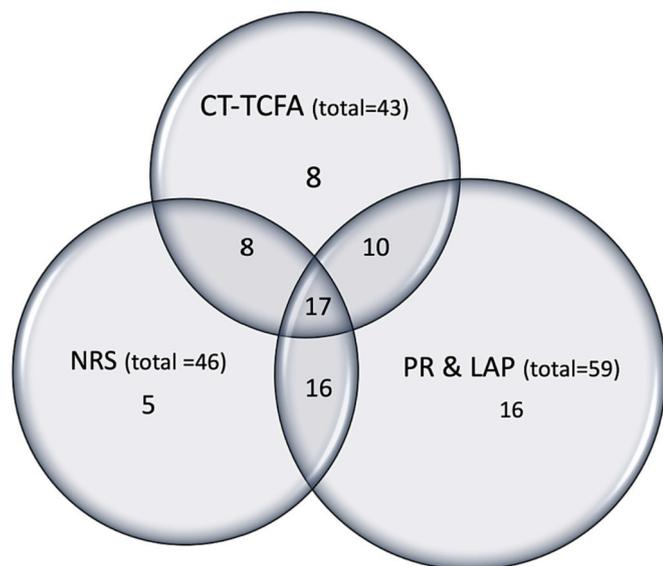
NRS and PR&LAP plaques overlapping with CT-TCFA. CT-TCFA = computed tomography defined Thin-cap fibroatheroma, NRS = Napkin ring sign, PR = Positive remodelling, and LAP = Low attenuation plaque.
